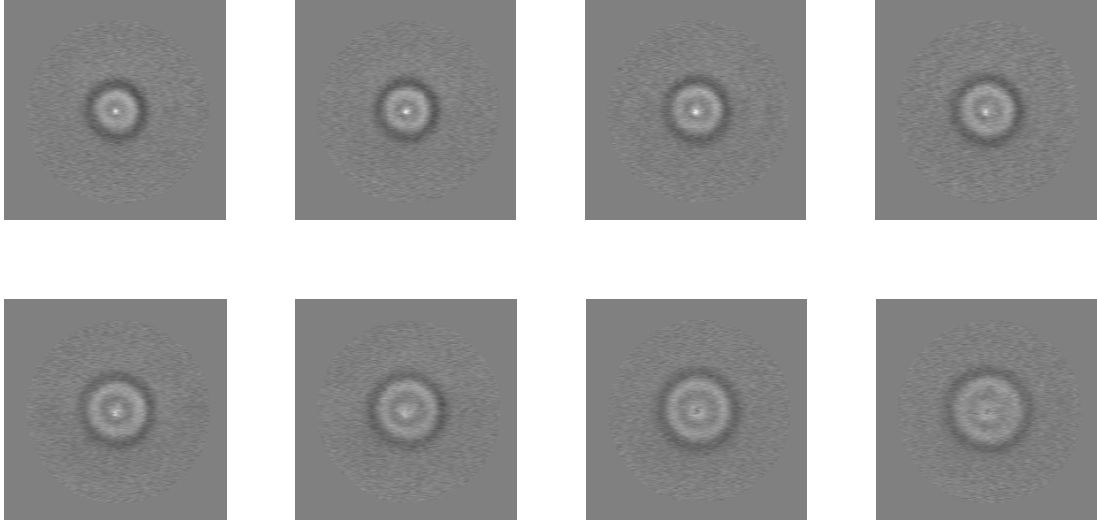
Typical series of eight consecutive shear wave images (located at the center of HIFU focus and perpendicular to the ultrasound beam) encoded with one pair of bipolar gradient at frequency 250Hz, HIFU impulse duration is 2ms, $P_{\max} = 250\text{W}$ (acoustic power). Each image is of $20 \times 20 \text{ cm}^2$. The images were separated by a time interval (or phase offset) $\Delta\tau = 0.4\text{ms}$. Gray scale is $-\pi/2$ to $\pi/2$ from back to white.
